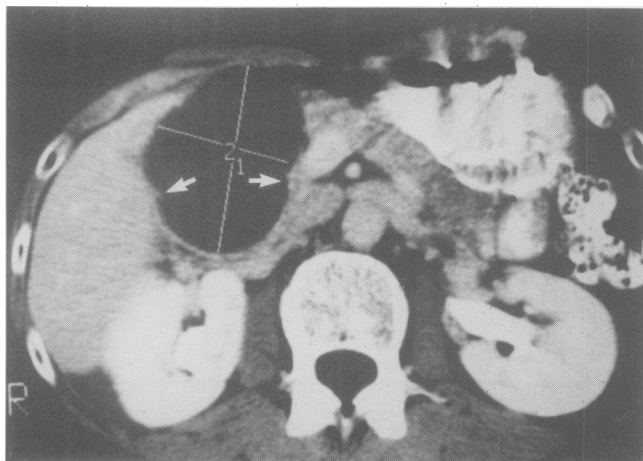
CT scan showing a large cystadenoma in the head of the pancreas (case 1). There is no associated mass seen, but the internal wall is slightly irregular (arrows).
